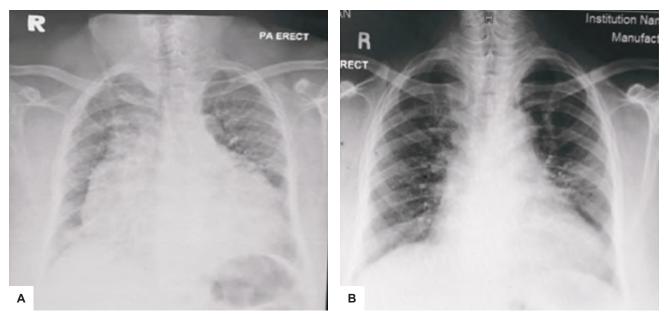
(A) PA erect chest radiography of Case 1 demonstrating cardiac shadow with globular appearance. (B) Chest radiography revealing reduction in cardio-thoracic ratio post commencement of thyroxine replacement therapy.
